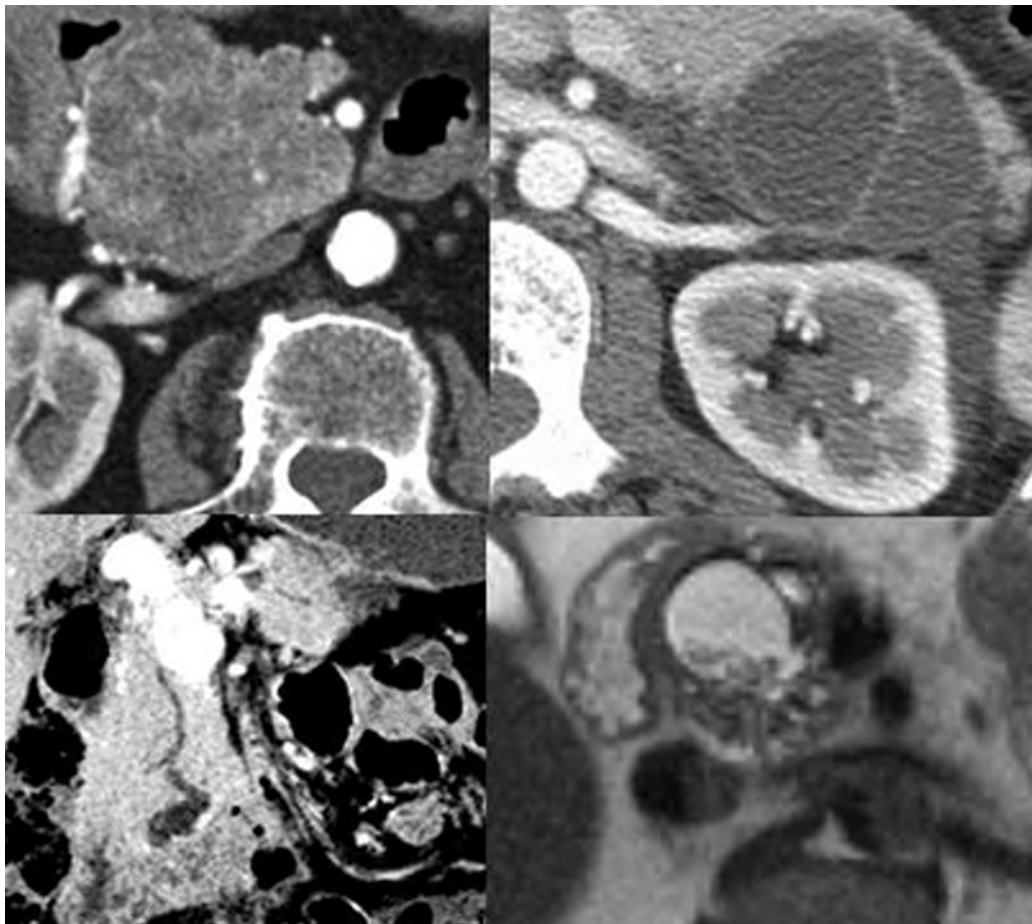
Pancreatic cystic neoplasms. Classic imaging findings in four different patients. *Top left:* Serous cystadenoma with radially arrayed dense septa. *Top right:* Mucinous cystic tumor in a 45-year-old woman. Note the scant septa and typical location in the pancreatic tail. *Bottom left:* Branch duct IPMN. The minimum intensity projection CT shows relation to main pancreatic duct. *Bottom right:* Walled off pancreatic necrosis. The presence of dependent debris on the T2-weighted image allows specific diagnosis. With current imaging technology and increasing appreciation of the appearances of pancreatic cysts, specific diagnosis can be made in approximately two thirds of cases.
